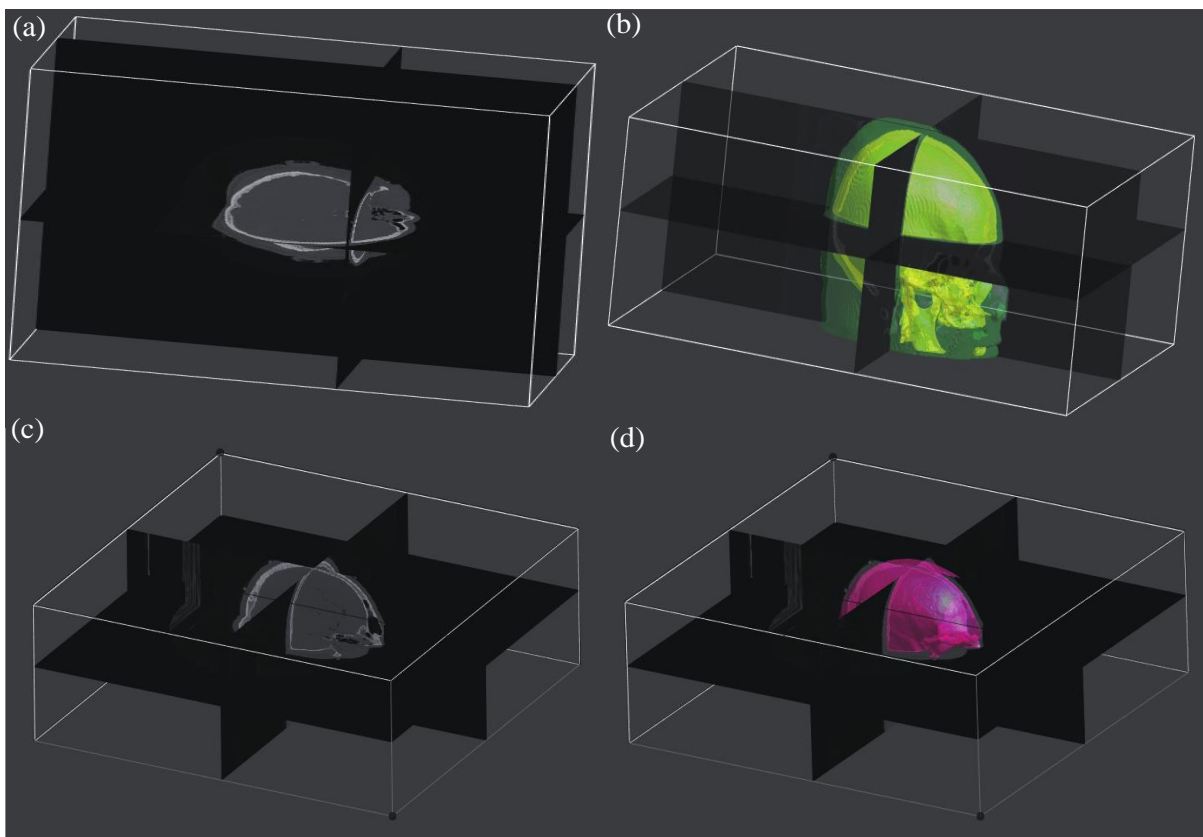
(a) CT scans of the anatomical female skull model. (b) Anatomical female skull model after segmentation. (c) CT scans of the anatomical male skull model. (d) Anatomical male skull model after segmentation
